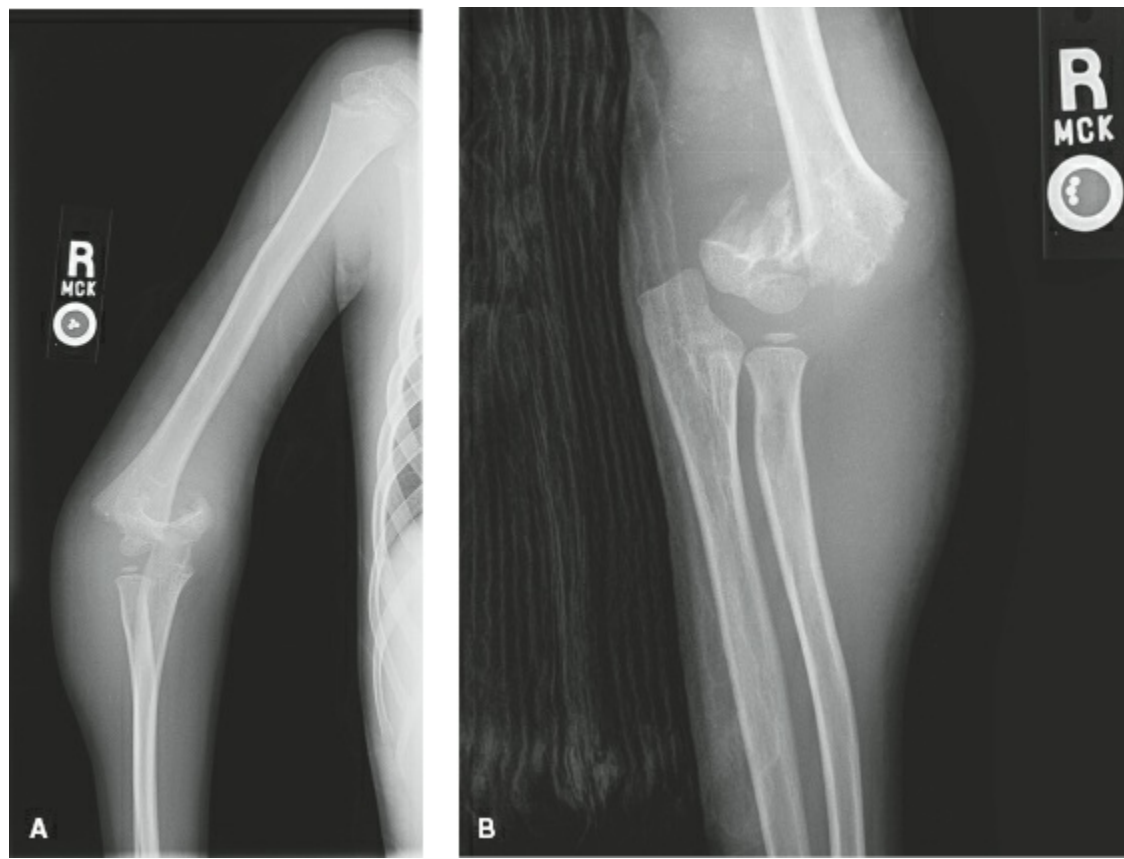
A,B: Radiographic images of a Gartland type III fracture of the right supracondylar humerus which is commonly associated with brachial artery injury.
